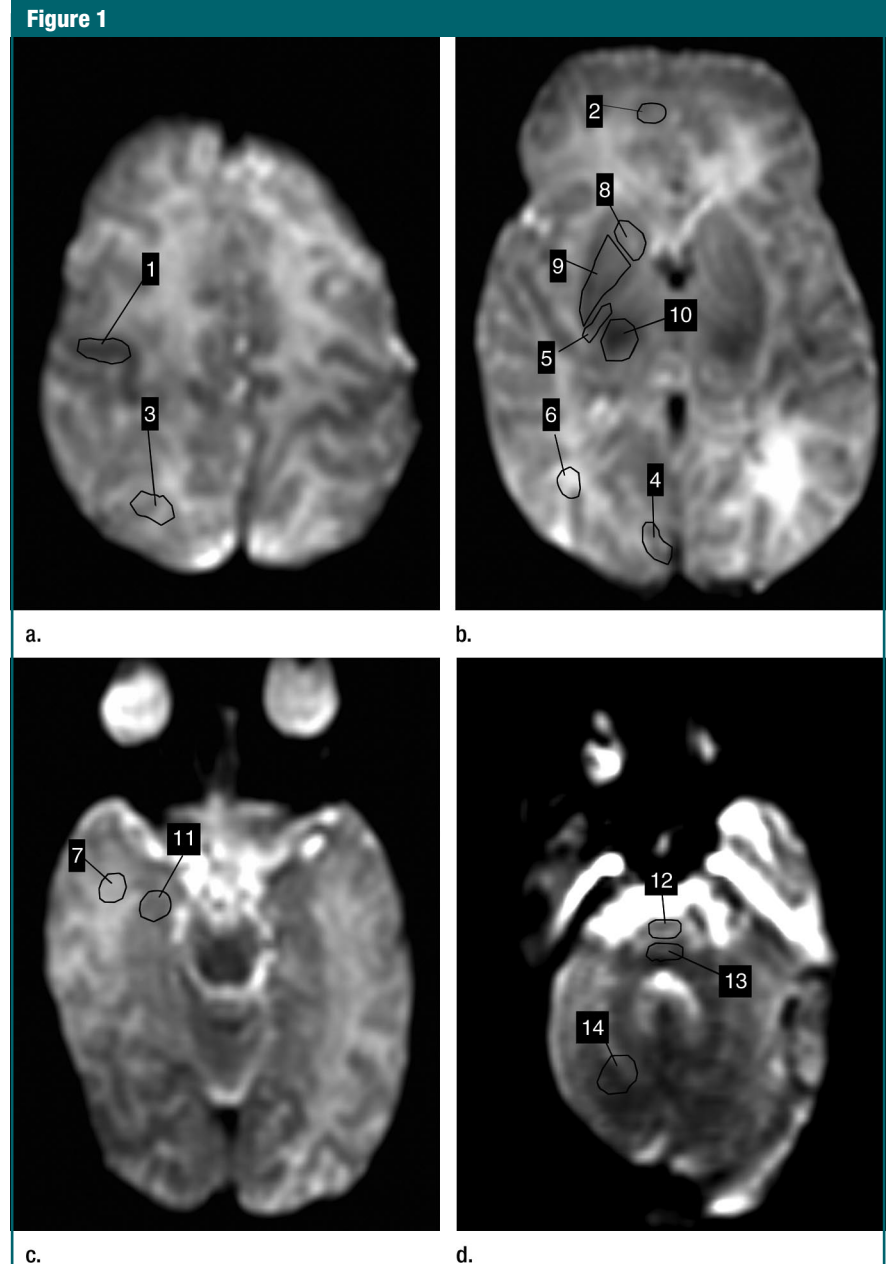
Placement of regions of interest on (a–d) MR images with low diffusion weighting ($b = 50$ sec/mm²). (a) 1 = Rolandic cortex, 3 = parietal cortex. (b) 2 = frontal cortex, 4 = occipital cortex, 5 = PLIC, 6 = occipital white matter, 8 = caudate nucleus, 9 = putamen, 10 = thalamus. (c) 7 = temporal white matter, 11 = hippocampus. (d) 12 = brainstem, anterior part; 13 = brainstem, posterior part, 14 = cerebellum. Regions of interest were subsequently transferred to ADC maps.
